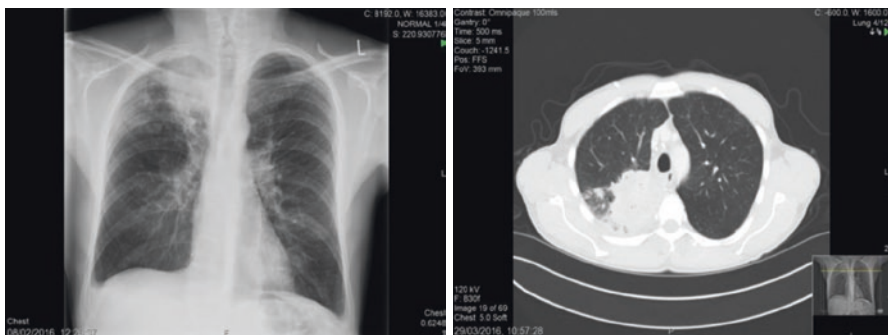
Chest X-ray and Computer Tomography scan of a 45-year-old man living with HIV presenting with features suggestive of pulmonary TB, mycobacterial sputum cultures isolated *Mycobacterium tuberculosis*, large right sided apical abscess, costophrenic blunting, volume loss and tracheal deviation
